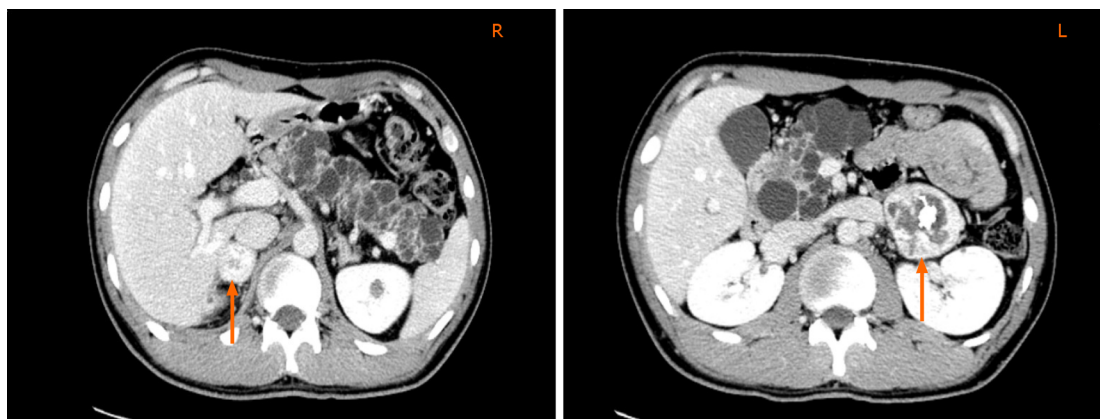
Bilateral adrenal gland masses. Bilateral adrenal gland masses on computed tomography are shown by the blue arrows, “R” and “L” represent the right and left side of the patient.
